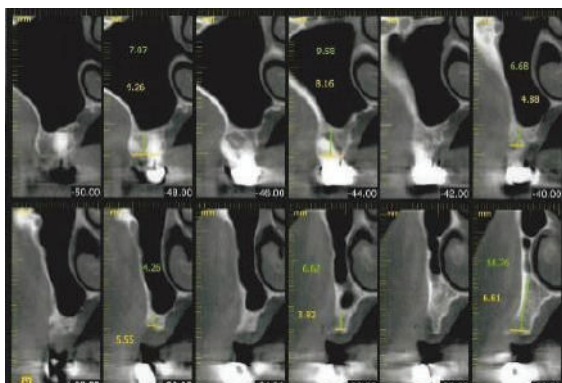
CBCT showing alveolar bone height of 5 mm in areas requiring augmentation procedure.
